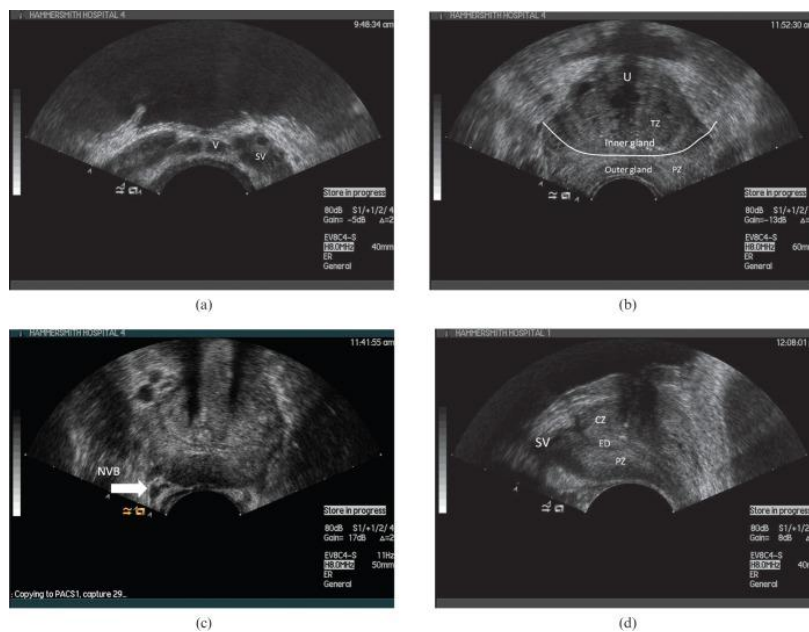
Axial transrectal ultrasound (a-c) and longitudinal images of the normal prostate (d).
